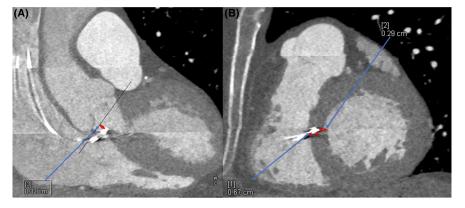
CT measurements of lead position using multiplanar reconstruction (measured distances denoted by red bilateral arrows). (A) Measurement of distance (mm) between His bundle pacing penetration point and level of aortic annulus—labeled [3]. (B) Measurement of depth of penetration of deep septal left bundle branch area pacing lead into muscular interventricular septum (mm)—labeled [1] and distance from the left ventricular septal wall (mm)—labeled [2].
